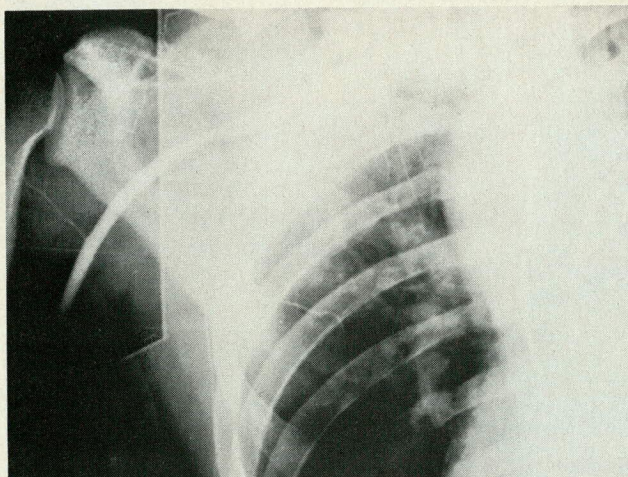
X-ray demonstrates severe multiple fractures of the left clavicle with displacement and with an intimal flap demonstrated in the distal subclavian artery.
